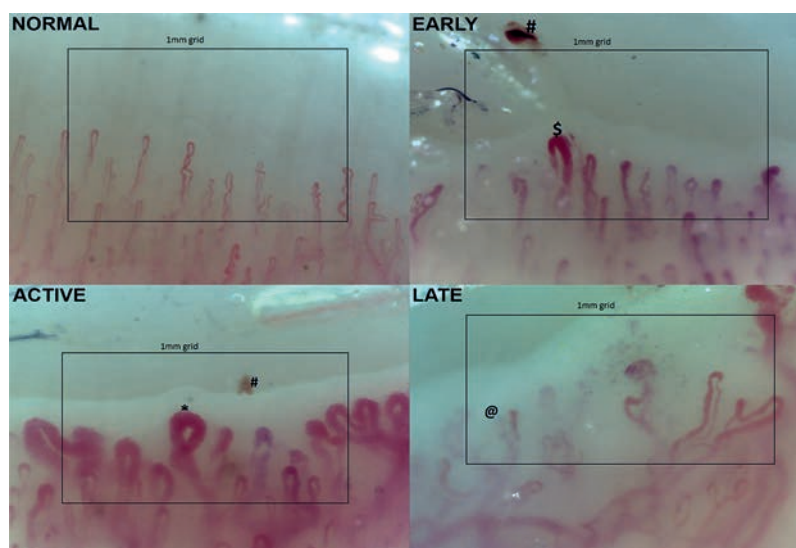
Nailfold videocapillaroscopy (NVC) images made with the INSPECTIS Pro. Examples of NVC images with a 1 mm grid. #: hemorrhages; \$: dilation > 30 μM ; *: giant (dilation > 50 μM); @: abnormal shapes (neangiogenesis)³³.
